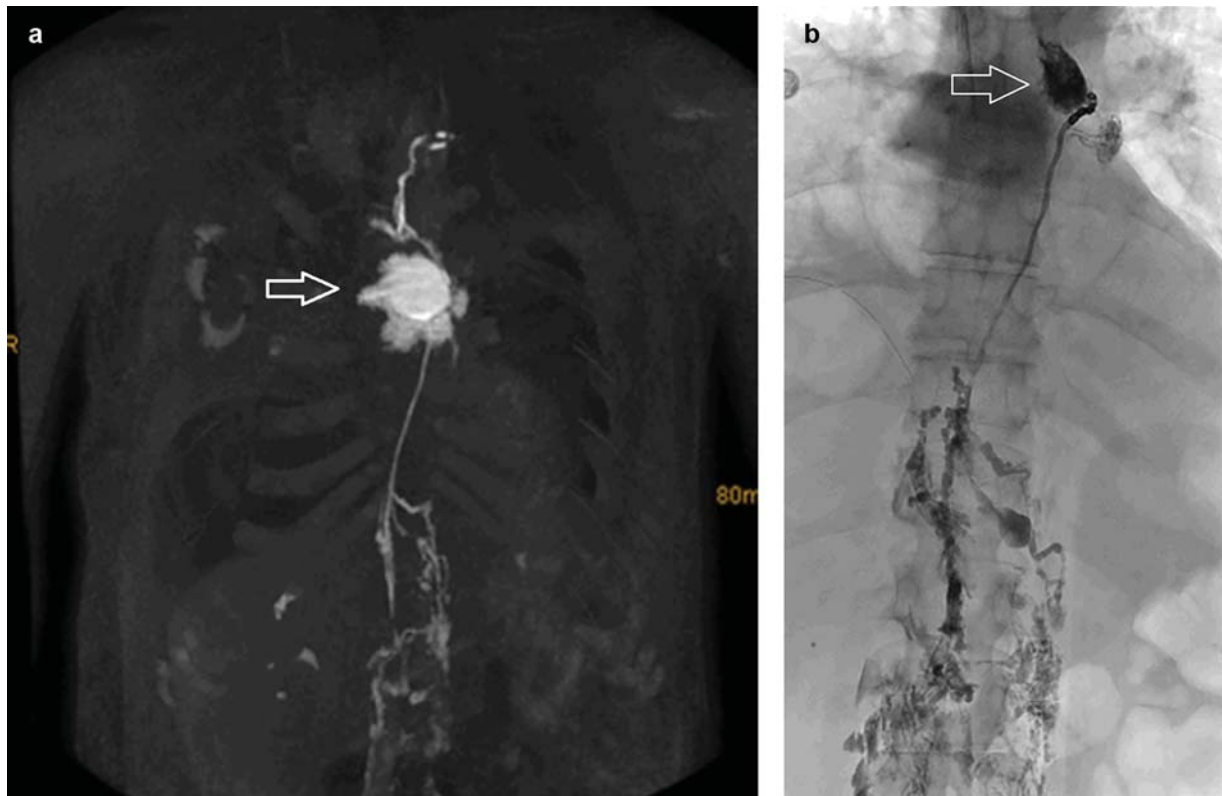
Traumatic chylothorax. A 79-year-old patient with a high-volume therapy refractory right-sided chylothorax after resection of esophageal cancer. (a) Coronal MIP MRL after intranodal contrast application showing enhancement of retroperitoneal lymphatics, the cisterna chyli, and the thoracic duct up to its termination in the left venous angle. There is a postoperative leakage from the thoracic duct as the cause of chylothorax (arrow). (b) Corresponding X-ray lymphangiogram after transabdominal thoracic duct embolization. Notice that using the oily contrast agent, there is no visualization of the thoracic duct above the leakage site (arrow).
